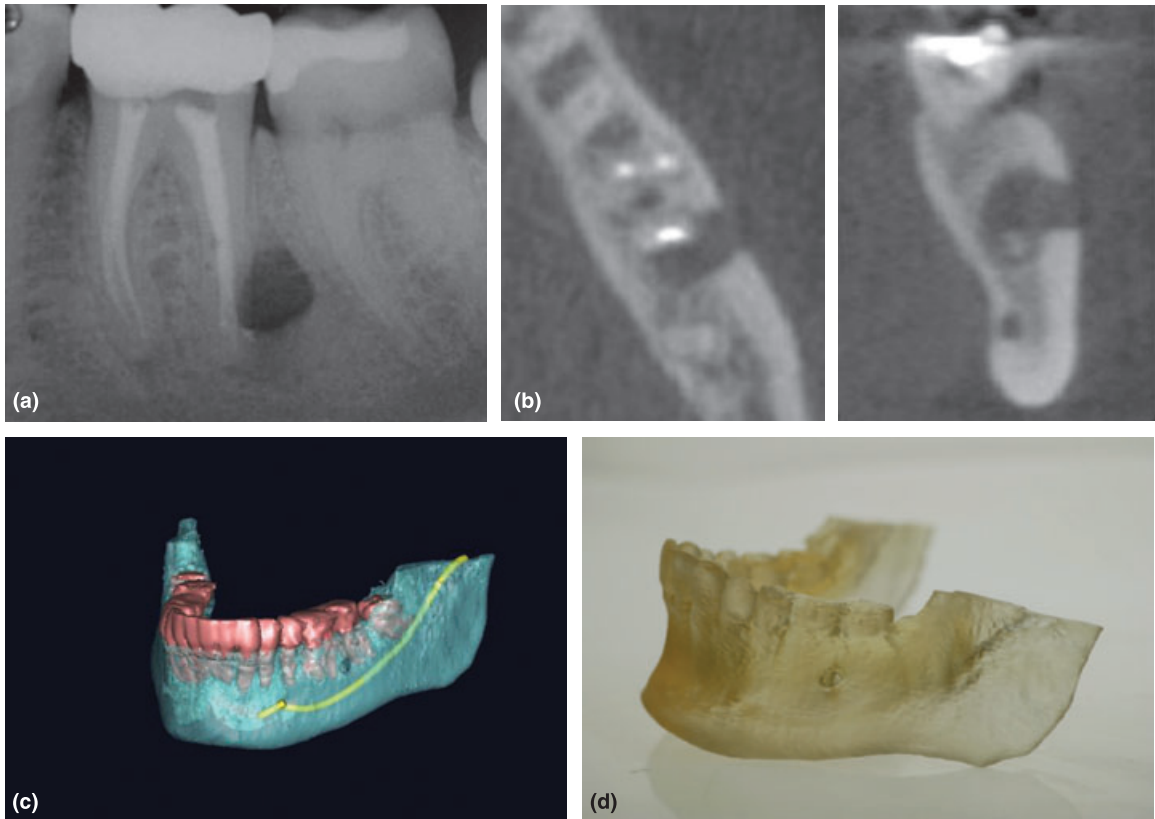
(a) A periapical radiograph of the lower left first molar with a failing root canal treatment and a large periapical radiolucency, periapical microsurgery is planned. (b) A cone beam computed tomography scan is taken, from this data orthogonal images can be reconstructed, (c) volume rendering allows true three-dimensional assessment of the roots, periapical tissues and adjacent inferior dental nerve to be assessed, (d) finally a rapid prototyping anatomical model has been manufactured, which allows the operator to tangibly assess the area to be treated.
